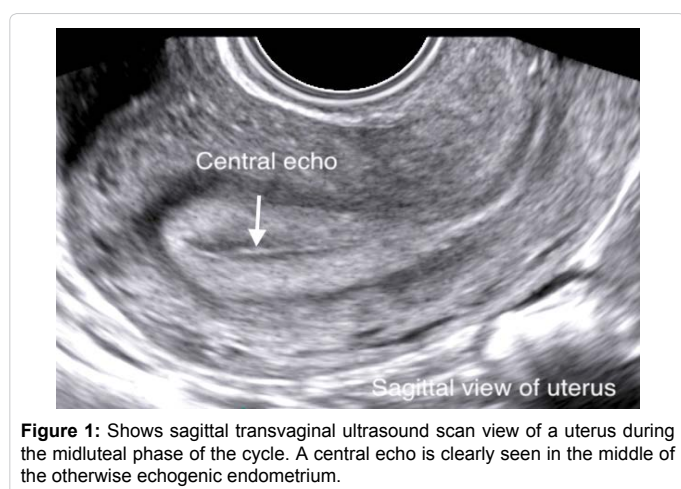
Shows sagittal transvaginal ultrasound scan view of a uterus during the midluteal phase of the cycle. A central echo is clearly seen in the middle of the otherwise echogenic endometrium.
